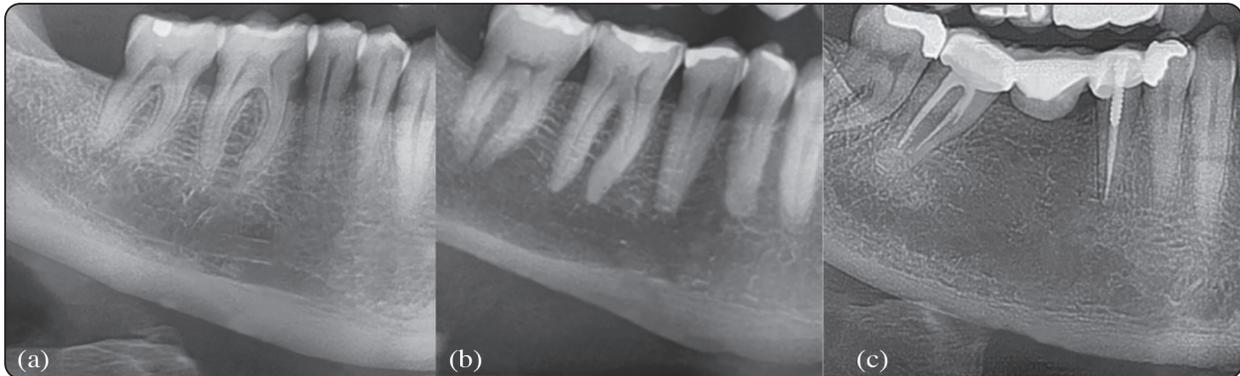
Panoramic radiograph showing morphology of mandibular cortices (MCI).
